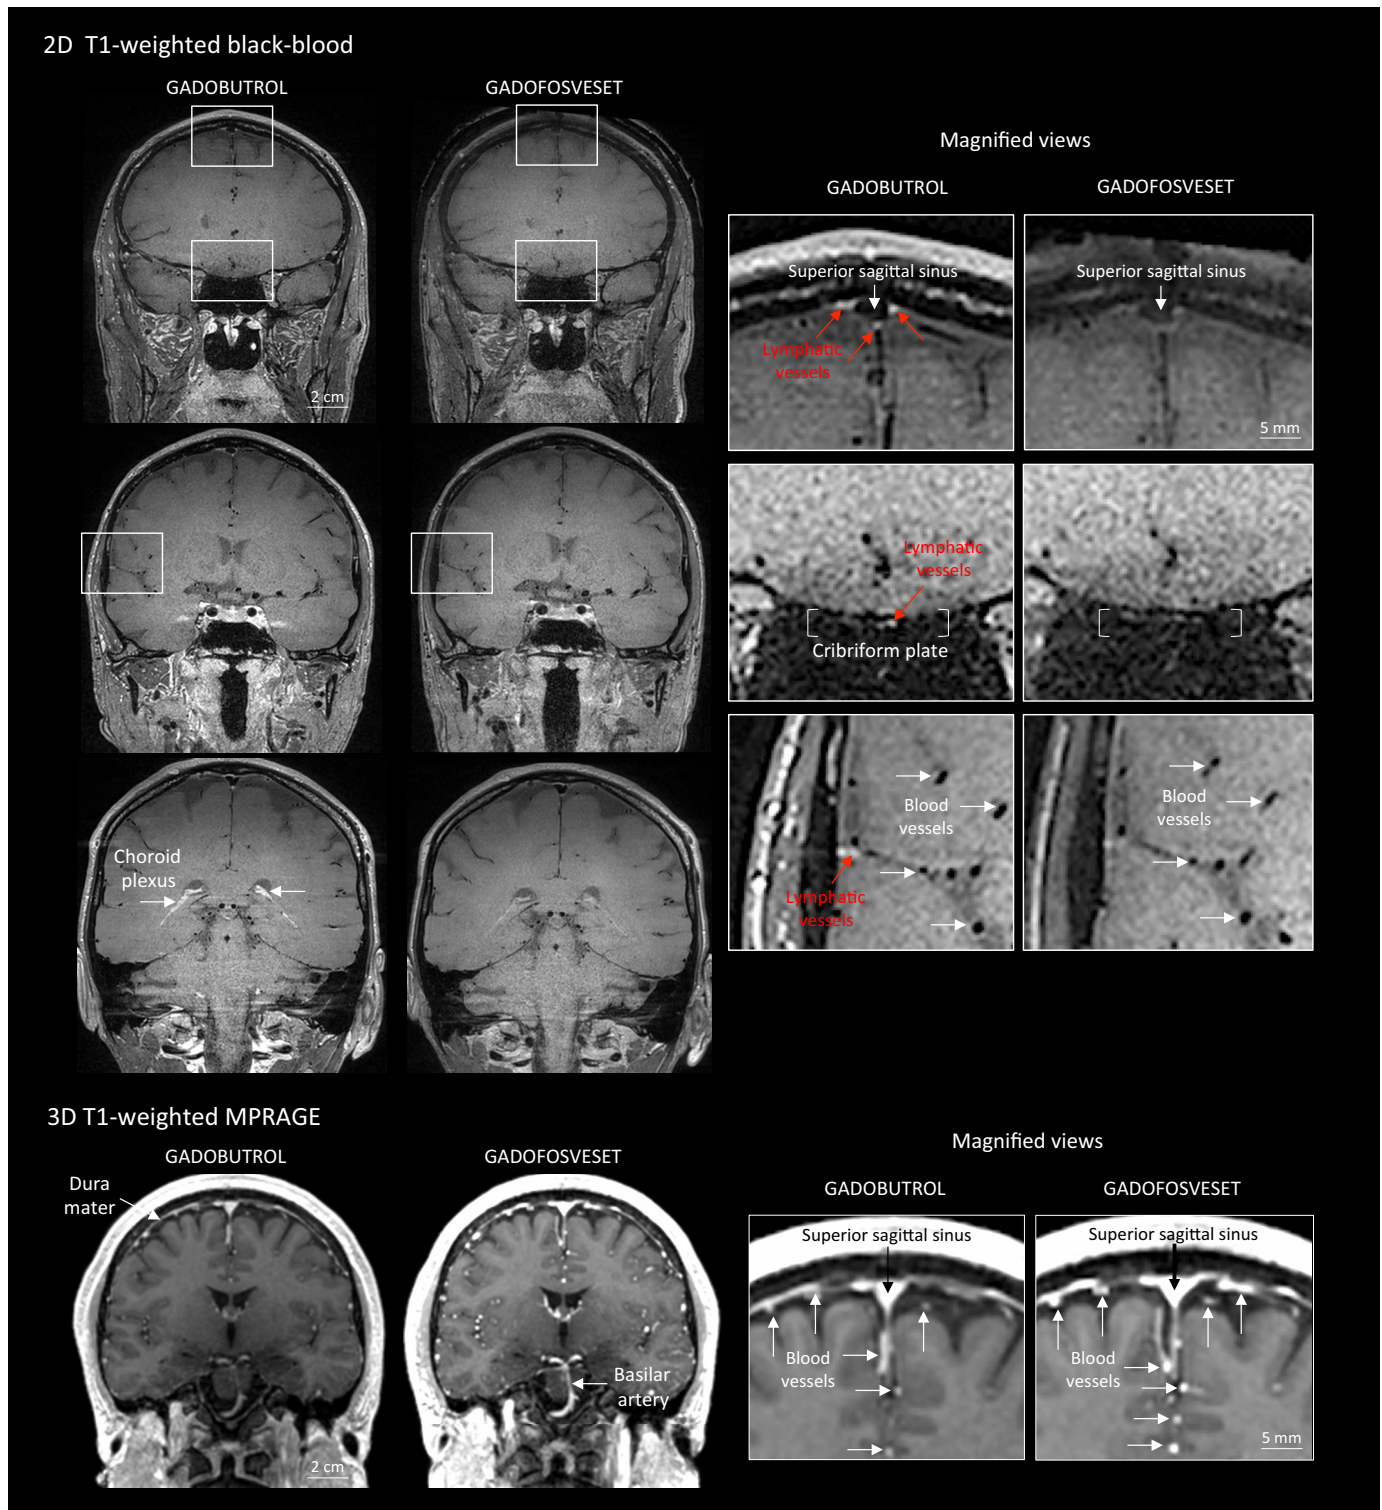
Gadobutrol vs. gadofosveset in MRI-visualization of dural lymphatic vessels. Coronal T1-weighted black-blood images were acquired after intravenous injection of two different gadolinium-based contrast agents (31 min after gadobutrol and 42 min after gadofosveset), during two MRI sessions separated by one week. Dural lymphatics (red arrows in magnified view boxes) were better discerned using gadobutrol (standard MRI contrast agent, which readily enters the dura) compared to gadofosveset (serum albumin-binding contrast agent, which remains largely intravascular) and were
